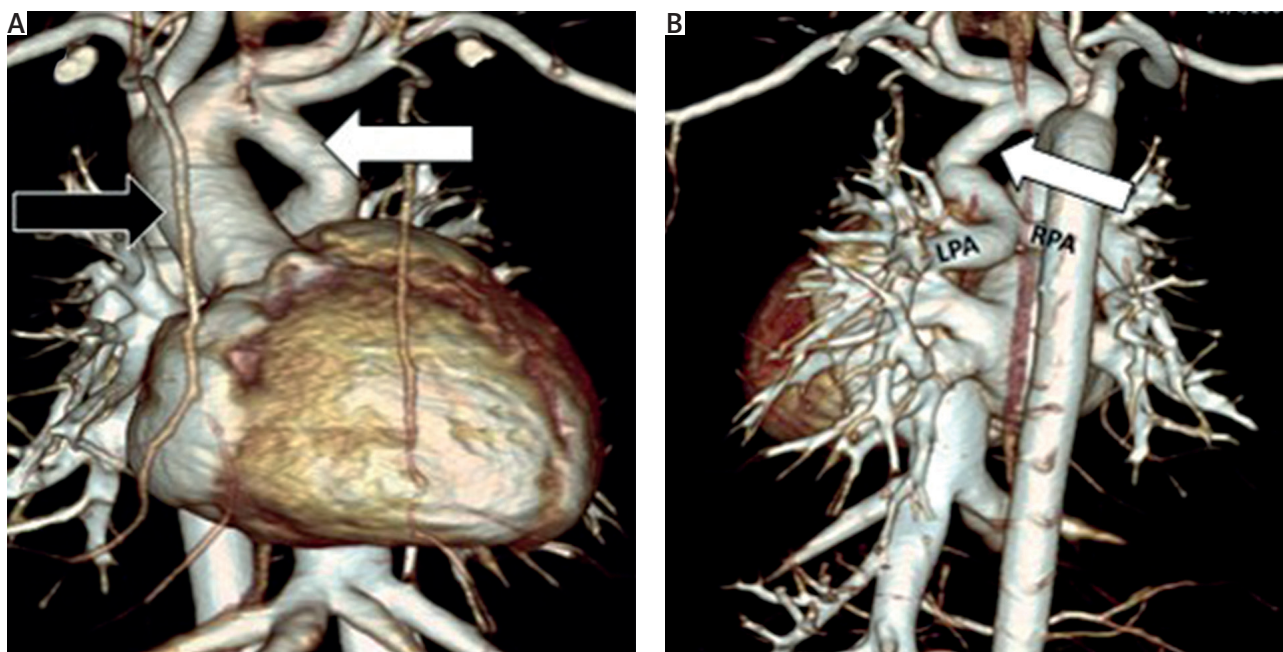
Cardiac computed tomography angiography (CCTA) of a 7-year-old boy with presumed diagnosis of tetralogy of Fallot. The CCTA showing new unexpected findings as pulmonary atresia with ventricular septal defect (PA-VSD), right-sided aortic arch (A; black arrow) and left-sided patent ductus arteriosus (A and B; white arrow) supplying pulmonary arteries causing a change in diagnosis which changed the therapeutic management from total corrected TOF to staged repair of pulmonary atresia with VSD
